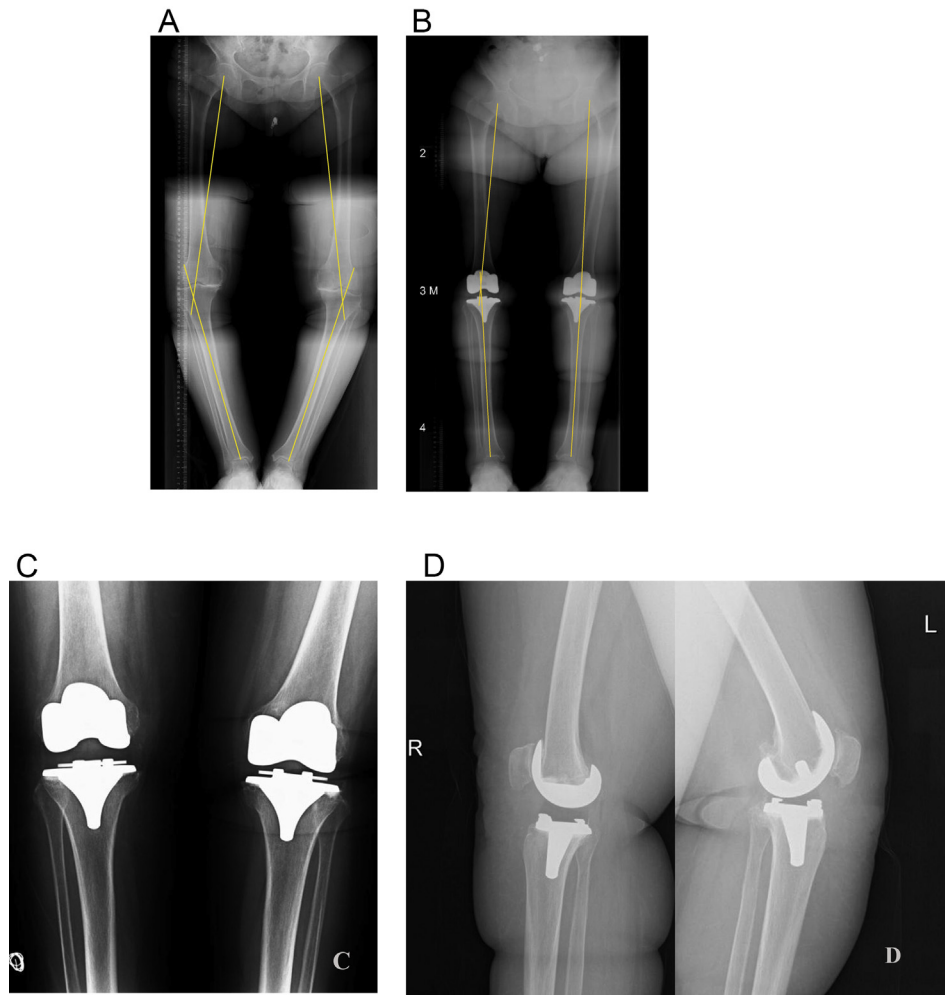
A 68-year-old woman with bilateral osteoarthritis of knee with severe varus deformity. (a) Preoperative orthoroentgenography revealed right and left varus alignment of 17° and 19°, respectively. (b) At 56 months follow-up for right knee and 62 months for left knee, postoperative orthoroentgenography revealed right and left valgus alignment of 2° and 6°, respectively. (c) Anteroposterior radiography at last follow-up visit. (d) Lateral radiographs of the same patient showing implantation of posterior cruciate ligament (PCL)-stabilizing prosthesis on right knee and PCL-retaining prosthesis on left knee.
